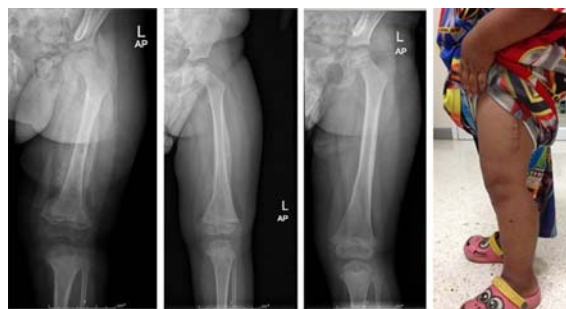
From left to right, the radiographs of the left femur at one, three, and six months after the treatment. There was profuse callus formation followed by bone remodeling. The child was fully recovered.
